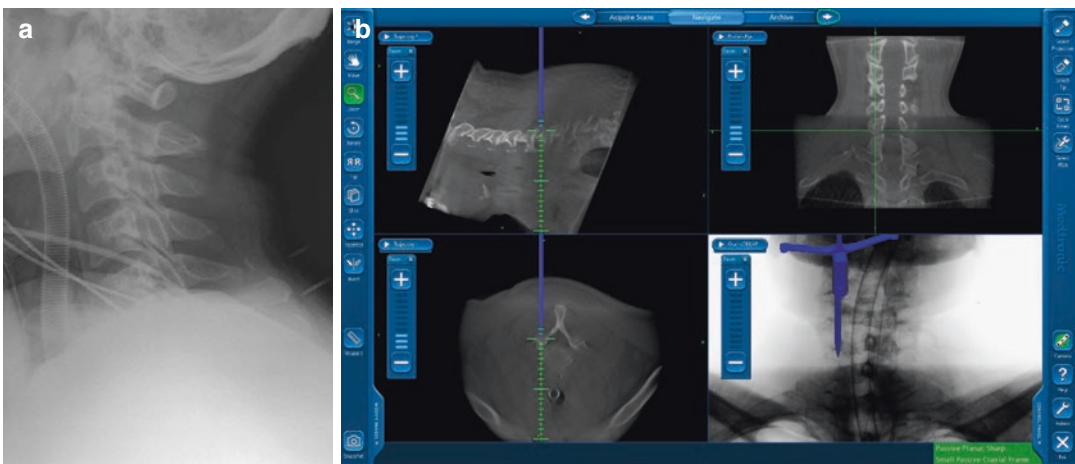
(a) Pre-operative radiograph showing the difficulty in finding the correct level (C6–7 level) for the surgical approach. (b) O-arm navigation images allowing proper localization of the level and laminofacet junction
